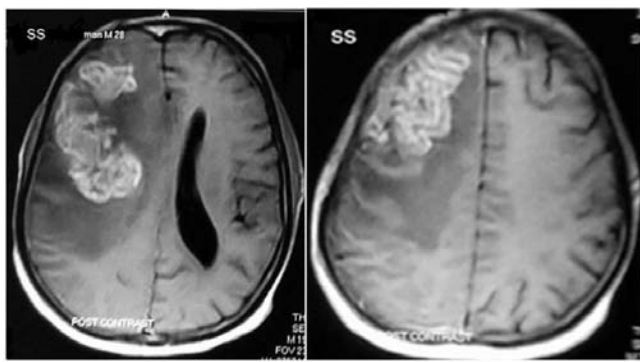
MRI T1 waited-image with contrast of a 28 year patient showed edema at the frontal and parietal lobe of the right cerebral hemisphere manifested as compression of the right lateral ventricle and mild deviation of the midline to the contra lateral side with gyral type of enhancement of the lesion after contrast administration that consistent with tuberculoma.
